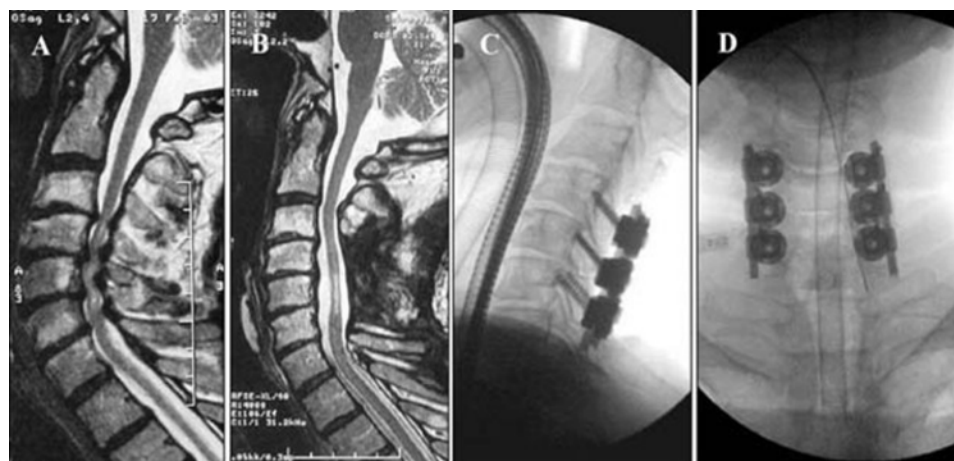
Preoperative (A) and postoperative (B–D) MR images of a patient with progressive myelopathy resulting from cervical spinal canal stenosis. A laminectomy and posterior instrumentation were performed. Sagittal postoperative imaging demonstrates sufficient decompression, but immediate loss of lordosis (B) due to intraoperative fixation (C). For the posterior instrumentation, lateral mass screws were used (C and D). The size of the screw heads might be a further handicap to achieving adequate lordosis, because big screw heads tend to touch each other even in a straight position.
